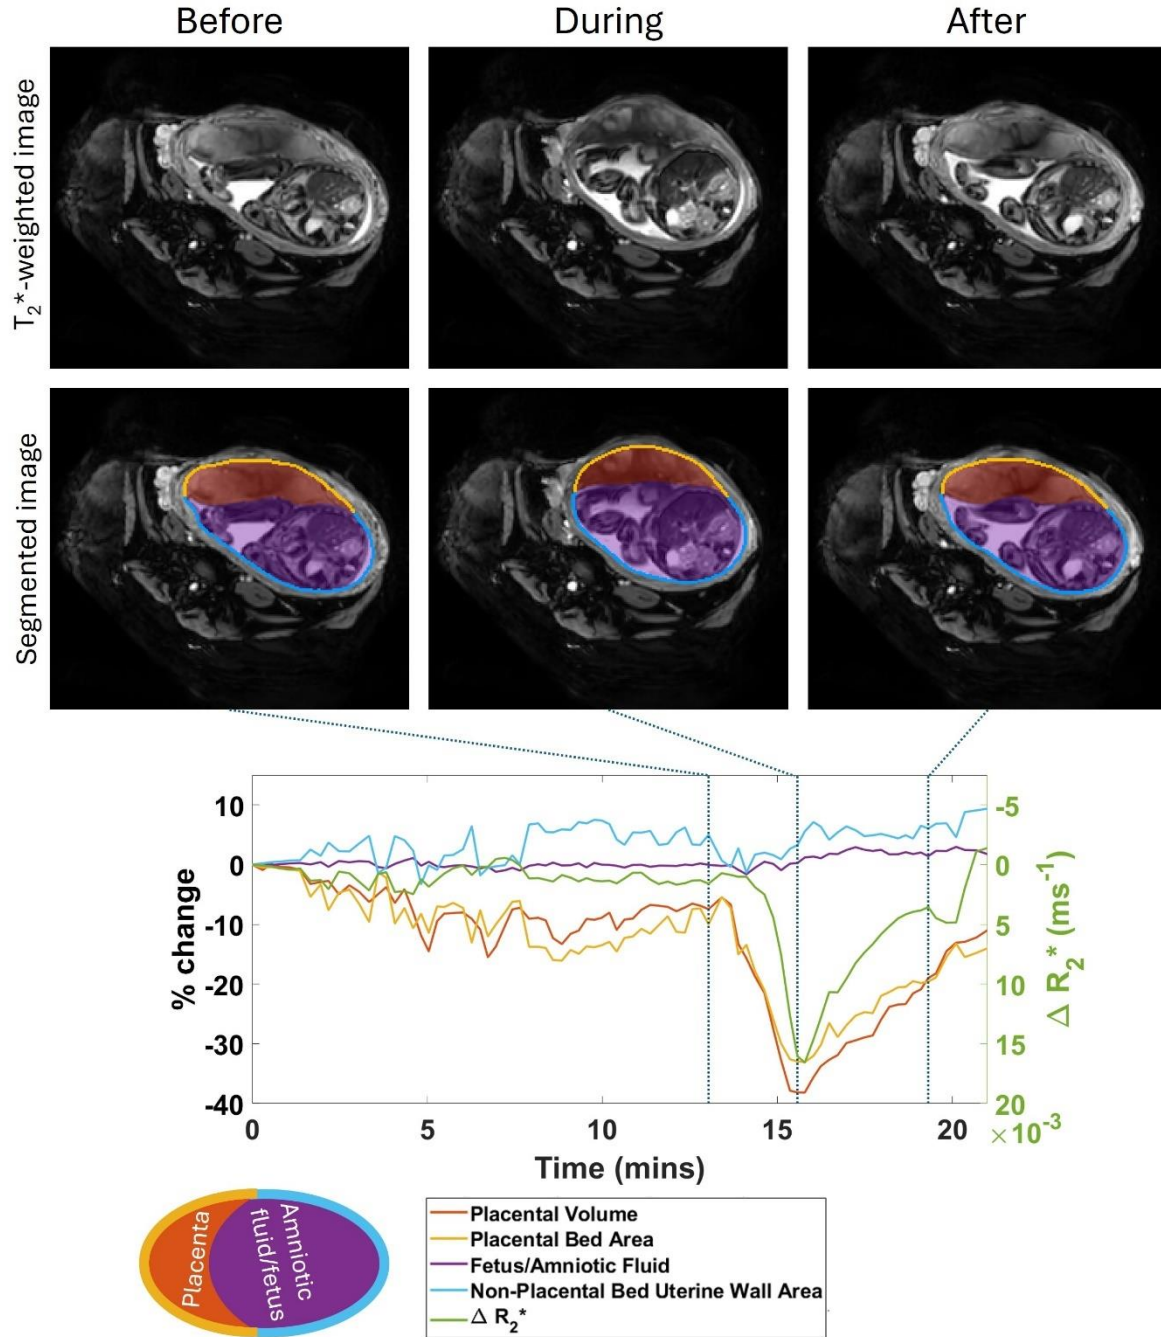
Uterine and placental changes during an example placental contraction. The top row shows axial MRI images at selected times points before, during and after a placental contraction (indicated by vertical lines on the graph below) with segmentations shown below. Changes in placental and non-placental volumes, wall areas and placental R_2^* (all measured across the whole volume of the uterus, not just the single slice shown) are plotted underneath. The legend indicates the colours used for the lines in the plots and the regions indicated in the segmentation.
